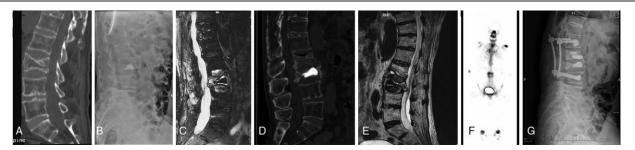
A preoperative lateral radiograph: a compression fractured L3 vertebra with an intraosseous cleft (A). Kyphplasty was used to treat L3 OVCF with PMMA cement (B). Two months later, MRI confirmed that bone marrow edema around the cement with high signal at the previously treated L3 level (C). Two weeks later, repeated CT and MRI examination of the lumbar spine confirmed a L3 vertebral refracture and 1 new OVCF at L2 level with an intravertebral cleft (D, E). ECT image further confirmed a L3 vertebral refracture (F). A kyphoplasty was used to treat L2 fracture and the pedicle screws reinforced with PMMA cement were inserted percutaneously at L1 and L4 levels (G). CT = computed tomography, ECT = emission computed tomography, MRI = magnetic resonance image, OVCF = osteoporotic vertebral compression fracture, PMMA = polymethylmethacrylate.
